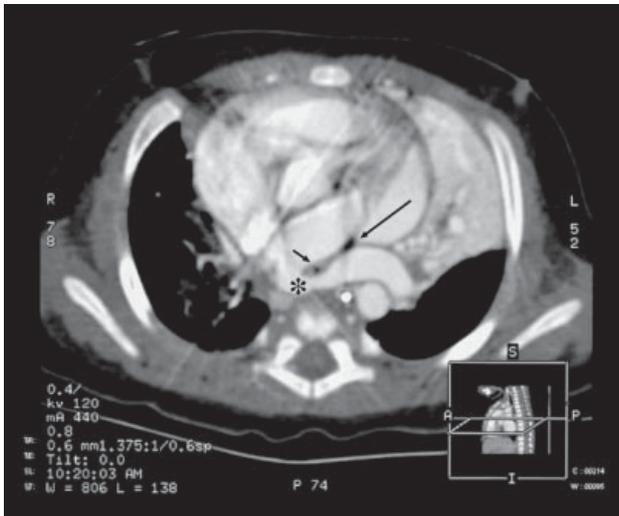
Axial computed tomogram of the thorax following intravenous contrast enhancement showing the aberrant left pulmonary artery (asterisk) arising from the right pulmonary artery, coursing behind the trachea, and causing compression and appreciable narrowing of the distal trachea (short arrow); and left upper lobe collapse consolidation with a patent left upper-lobe bronchus (long arrow).
